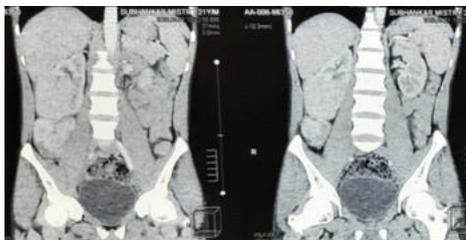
Coronal sections of Computed Tomogram showing right renal angiomyolipoma with perinephric haematoma
